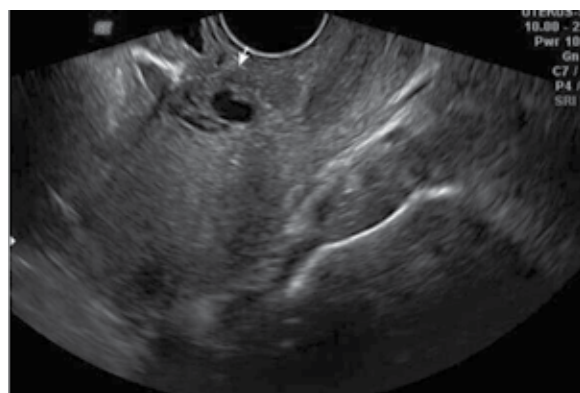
Grey scale ultrasound image of lower segment caesarian section scar AVM.
